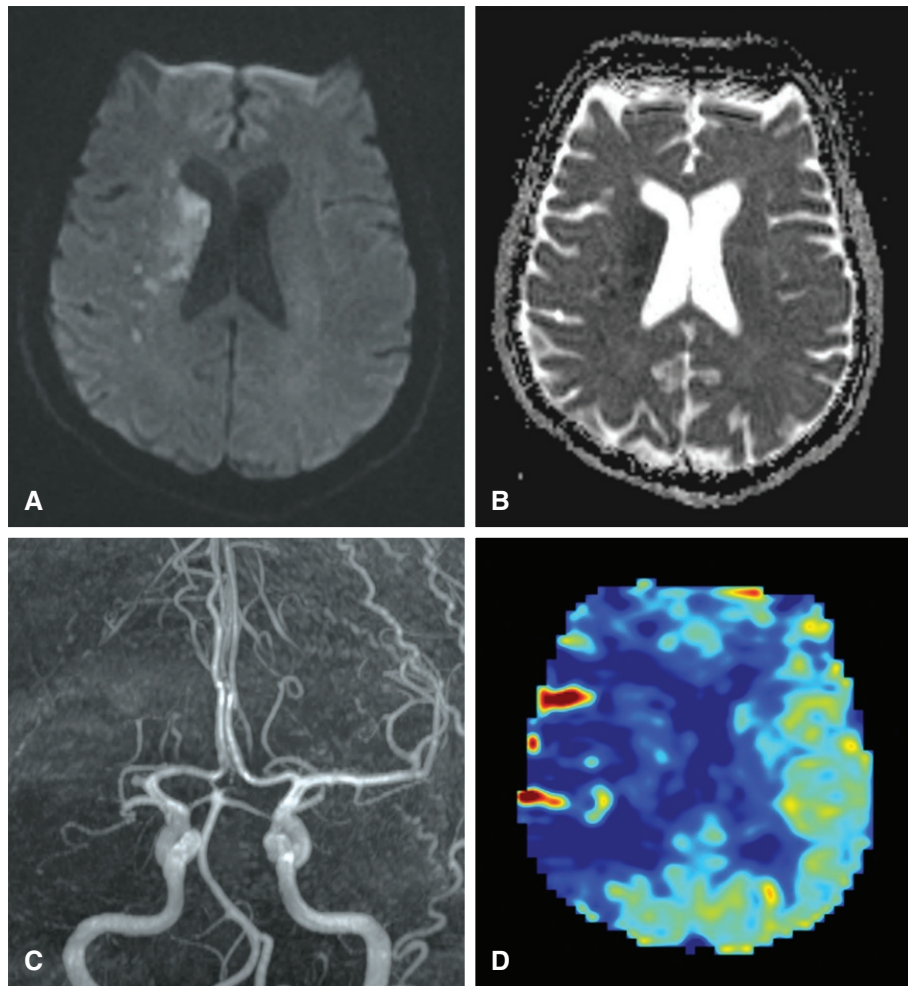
A 57-year-old female who presented with left pronator drift and right gaze preference. She was found to have right middle cerebral artery territory infarct involving right basal ganglia and periventricular white matter on diffusion-weighted imaging (DWI) (A) and apparent diffusion coefficient (ADC) (B) maps. Time-of-flight magnetic imaging angiogram (C) showed abrupt cut-off of right middle cerebral artery in M1 segment. Arterial spin labelling (ASL) map (D) showed reduced perfusion in right MCA distribution.
